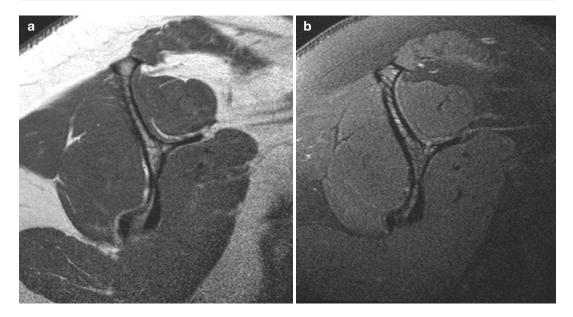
MRI of a normal muscle: (a) rotator cuff muscles on T1 and (b) T2FS
